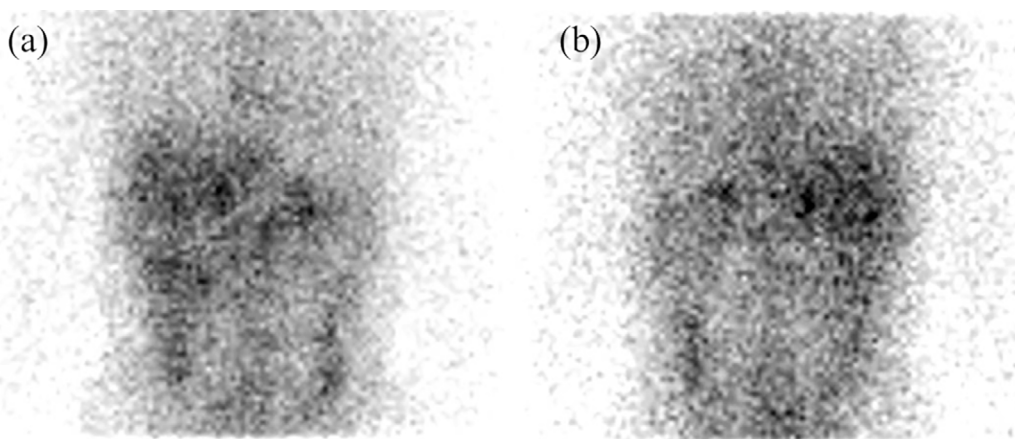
Iodine-131 adsterol scintigraphy findings. Iodine-131 adsterol scintigraphy showed normal uptake in both adrenal glands (right, 2.1%; left, 1.4%). a: Anterior, b: Posterior.
